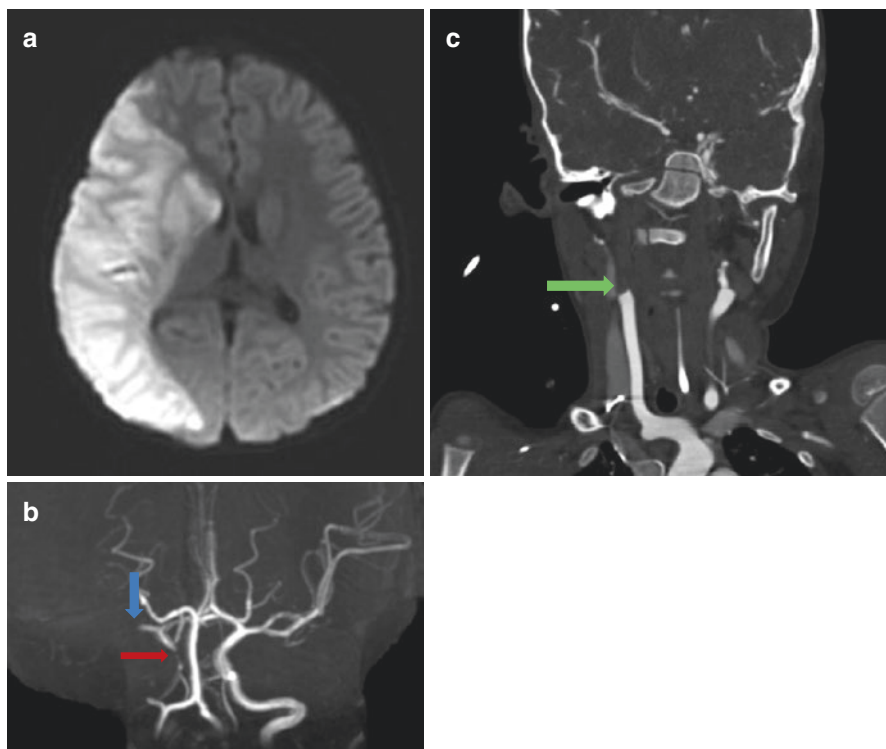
A 3-year-old boy presents with acute onset left hemiparesis involving the face, arm and leg. Axial MRI diffusion-weighted imaging demonstrates complete right middle cerebral territory infarct (a); MR time-of-flight angiography demonstrates absent flow through the cavernous portion of the right internal carotid artery (*red arrow*), with reconstitution of flow at the supraclinoid internal carotid artery, and subsequent loss of flow signal in the proximal MCA (*blue arrow*), suggesting occlusion from artery-to-artery embolism (b); contrast-enhanced CT angiography demonstrates an abrupt cut-off at the carotid bifurcation (*green arrow*) suggesting arterial dissection (c)
